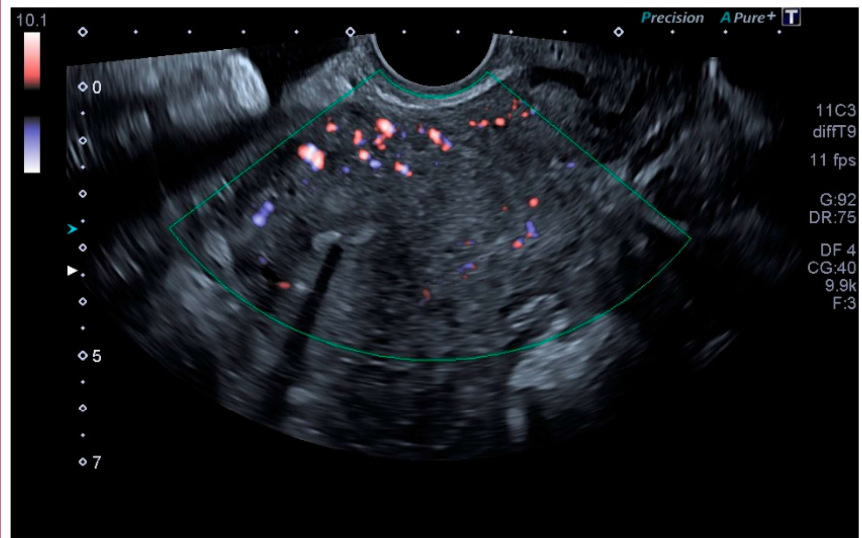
Transvaginal ultrasound image of the uterus. Multiple tortuous arcuate veins were seen in the myometrium on color Doppler.<sup>24</sup>
